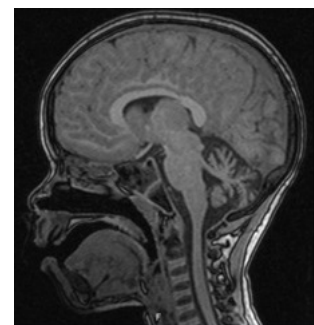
Brain MRI showing diffuse cerebellar atrophy.
